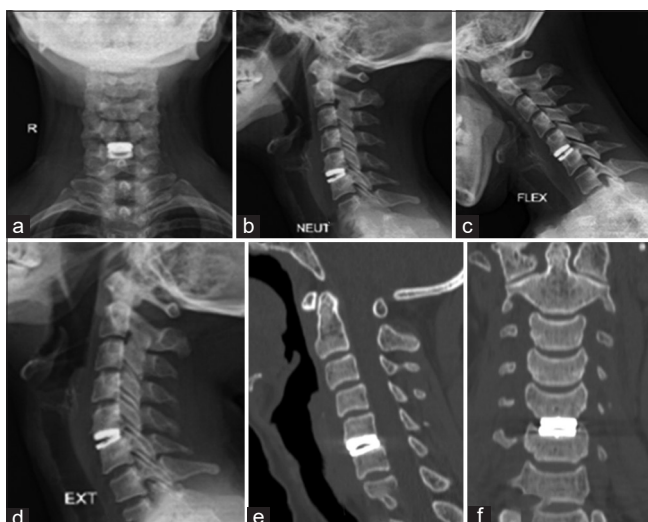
Postoperative X-ray of patient with total disc replacement – anterior-posterior view (a), lateral view-neutral (b), lateral view – flexion (c), lateral view – extension (d); Postoperative computed tomography scan of patient with total disc replacement -sagittal view (e), coronal view (f)
